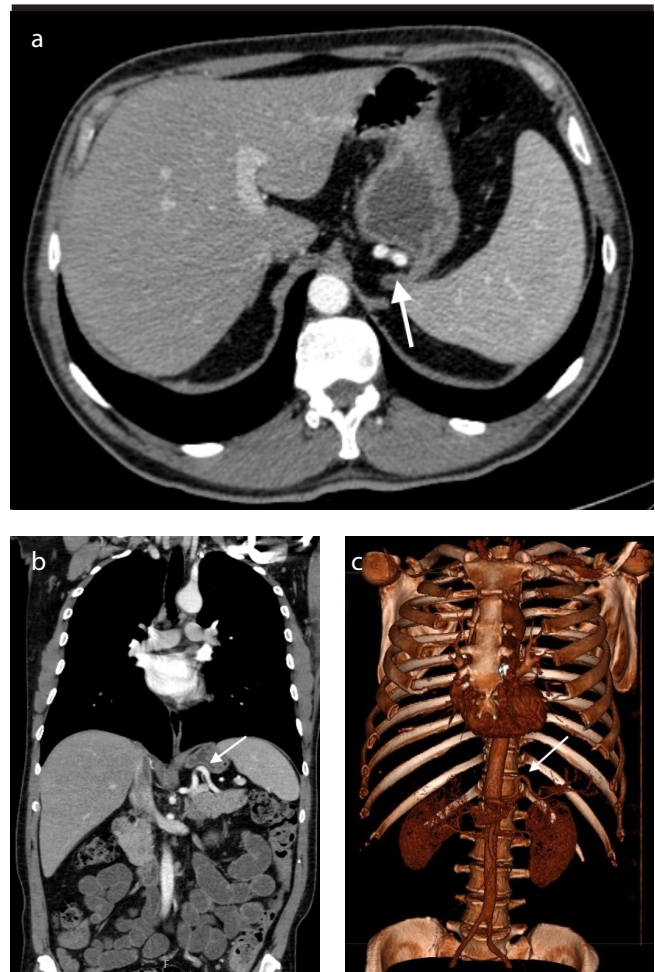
a-c. Axial b. Coronal CT images representing arterial loop of tortuous splenic artery at the distal part of great curvature (Arrow). c. 3D reformatted CT image showing loop of tortuous splenic artery (Arrow).
